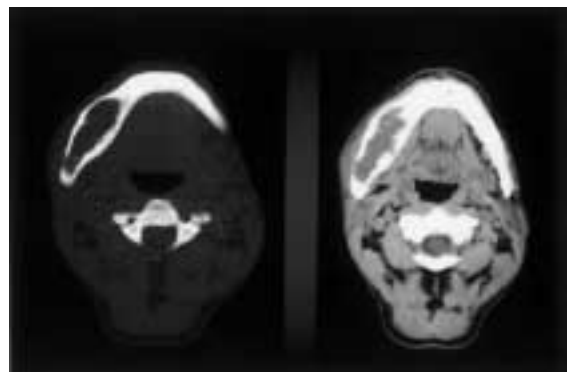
CT image (Axial scan).
